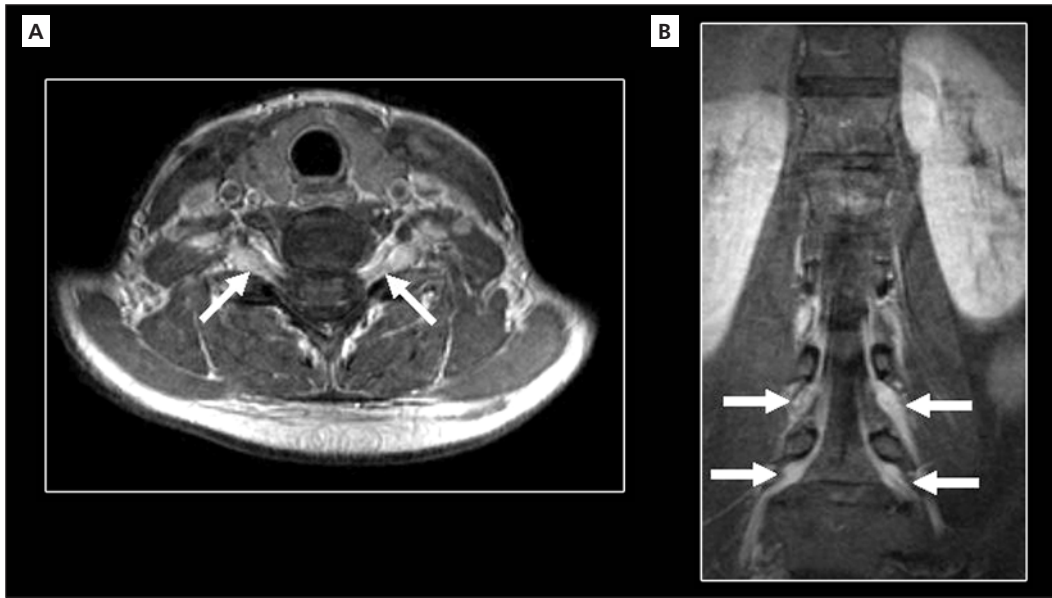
Axial T1-weighted post-contrast image, at the approximate level of Figure 1, demonstrates enhancing cervical spinal nerve roots (arrows) (A). Diffuse thickening and enhancing of nerve roots are exhibited on T1-weighted post-contrast image (arrows) (B).
